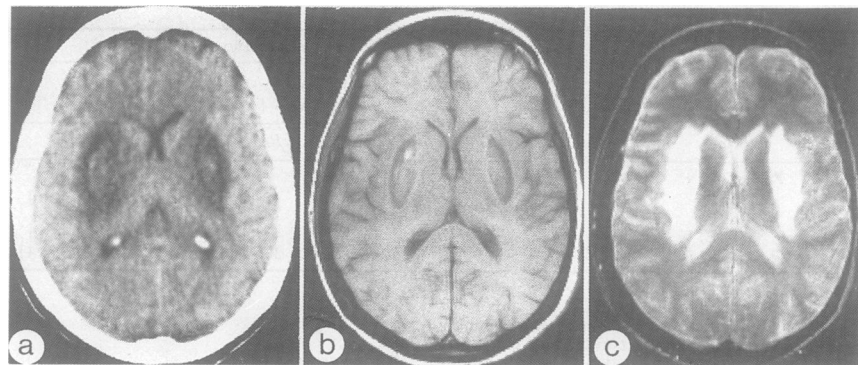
(a) First non injected CT scan five days after intoxication. Bilaterally symmetrical, low density lesion in the putaminal region with central isodense zone possibly suggesting microhaemorrhages; (b) MRI scan: T1 weighted axial section (TR = 450ms; TE = 28ms). Bilateral putaminal lesions; (c) T2 weighted sequence (TR = 2000ms, TE = 120ms). High signal intensity of the basal ganglia and the periventricular white matter suggesting major oedematous participation.
